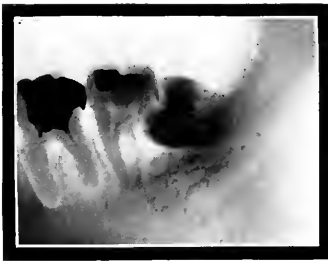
Radiograph of an impacted inferior third molar, with a large cavity in the distal root of the second molar.
